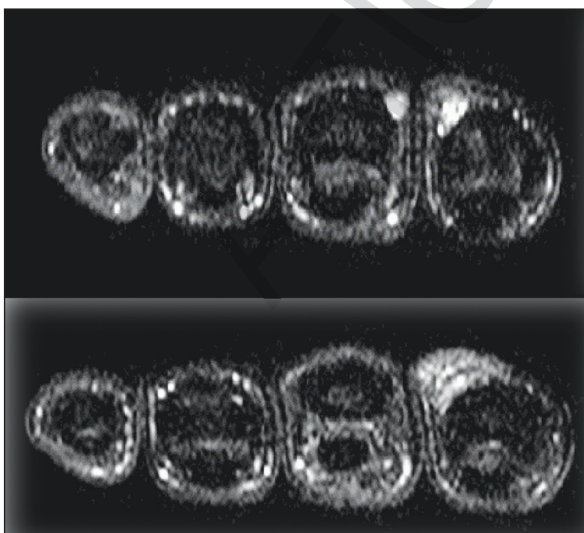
Axial section view of the malformed structure and mass on the 2nd and 3rd fingers in contrast-enhanced magnetic resonance imaging of the left hand
